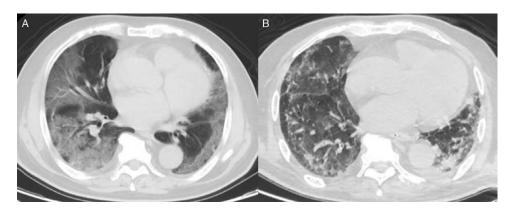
Chest computed tomographic images of post-ARDS pulmonary fibrosis in a 66-year-old COVID-19 patient. The patient was admitted to the ICU on January 8, 2020. Transverse chest CT images showed ground-glass opacity and condensation shadows upon ICU admission (A) and pulmonary fibrosis on February 25, 2020 (B). The patient underwent tracheostomy due to ventilator dependence and died on March 16, 2020 due to secondary infection. ICU indicates intensive care unit; COVID-19, coronavirus disease 2019; ARDS, acute respiratory distress syndrome; CT, computed tomography.
